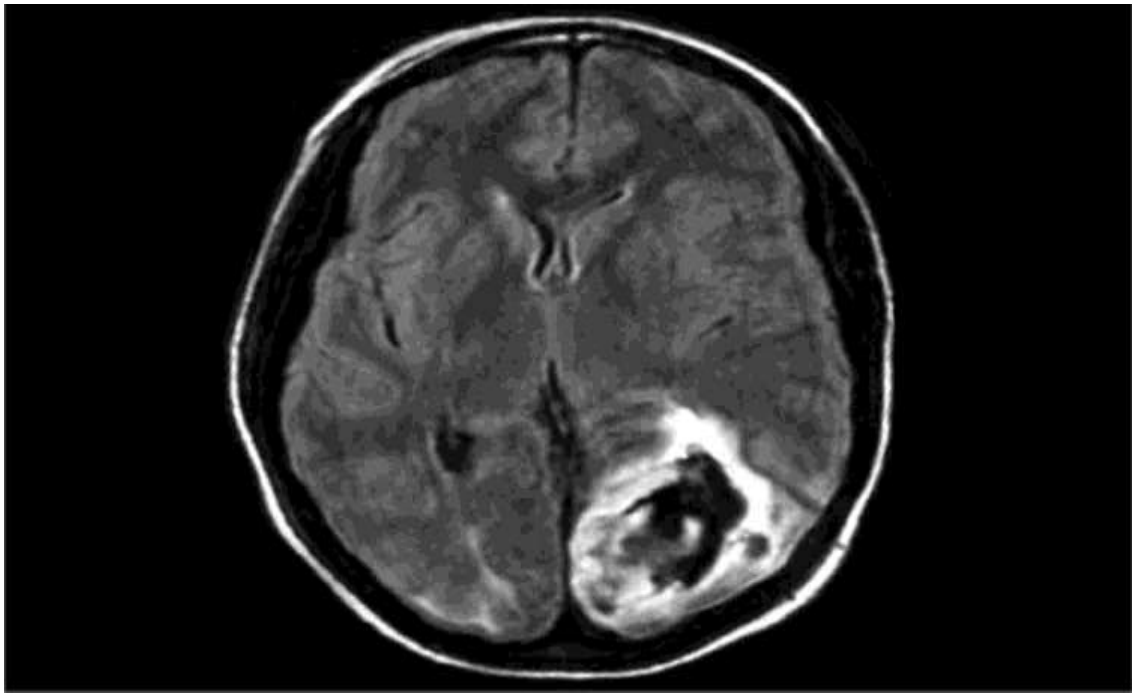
Cranial magnetic resonance imaging performed 3 days postpartum in a woman with eclampsia and HELLP syndrome. Neurovisual defects persisted at 1 year, causing job disability.
